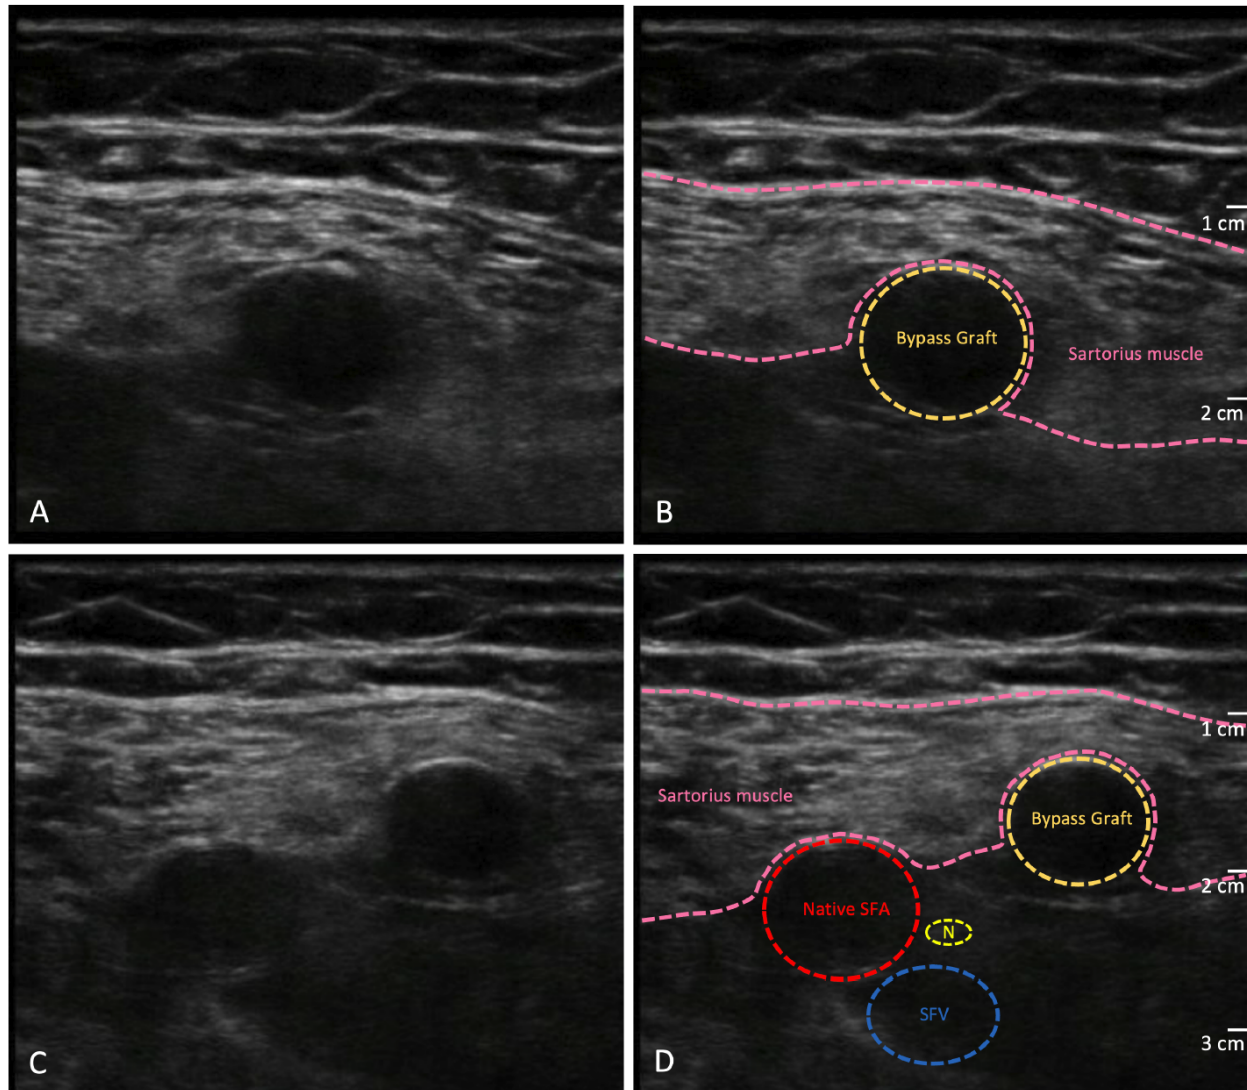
Large pulsatile structure identified as bypass graft (*gold*) deep to sartorius muscle (*pink*) [Panels A, B]. Native SFA (*red*), saphenous nerve (*yellow*) and SFV visualized with increased depth of ultrasound field of view [Panels C, D]. SFA, superficial femoral artery; SFV, superficial femoral vein.
